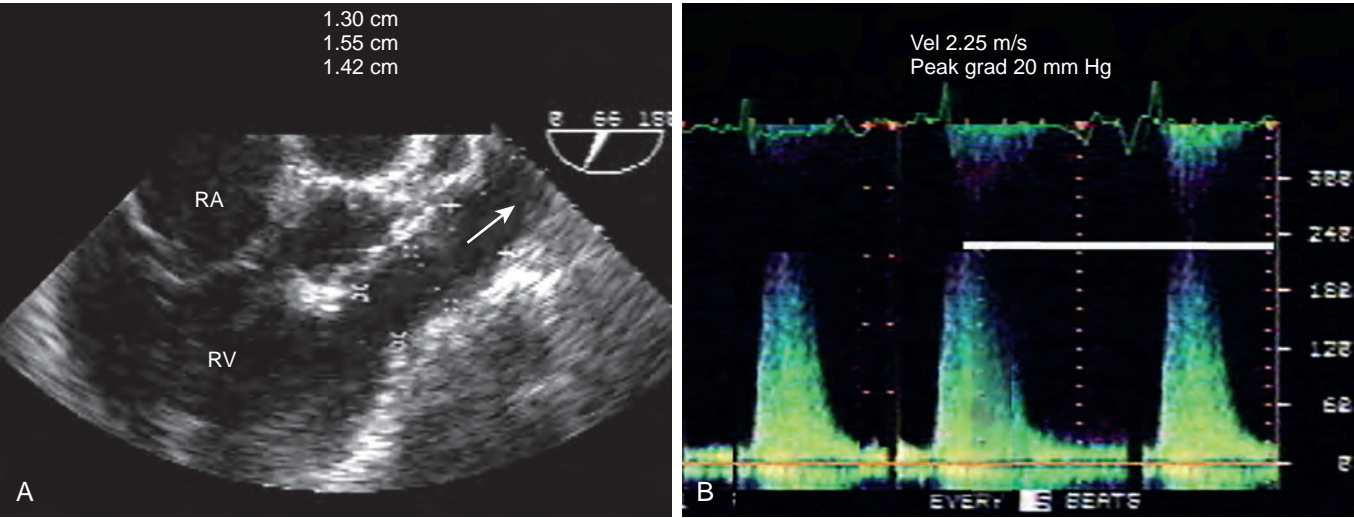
Right ventricular outflow narrowing. From these midesophageal windows (A) the right ventricular outflow tract appears narrow. (B) Continuous-wave Doppler analysis reveals an elevated gradient of 20 mm Hg. Relief of this obstruction requires a prosthetic patch and outflow enlargement. *Peak grad*, Peak gradient; *RA*, right atrium; *RV*, right ventricle; *Vel*, velocity.
